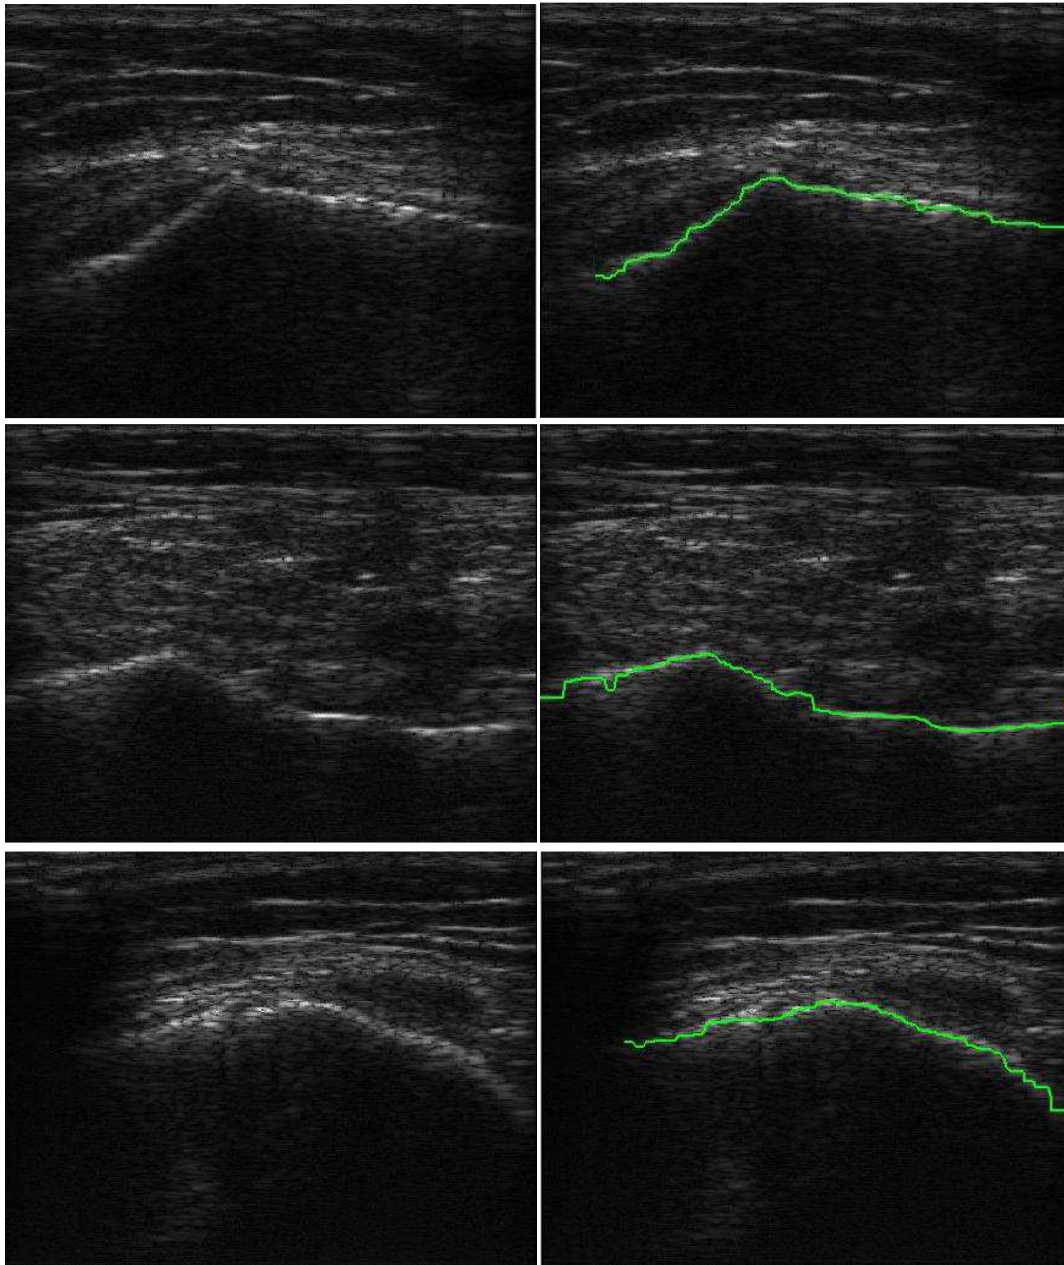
Ultrasound B-mode image (left), reconstructed by applying Hilbert transform to the ultrasound RF data, for a different regions of a cadaveric knee, and the extracted bone contour from the RF data overlaid on the B-mode image (right)
